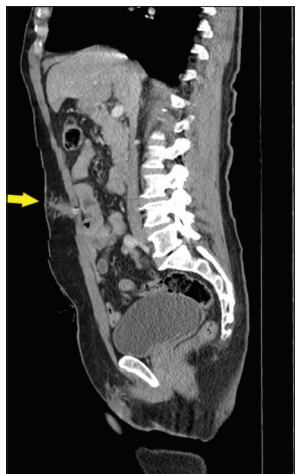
The yellow arrow indicates the peri-umbilical stab wound area on the sagittal plane of the CT scan. CT: Computed tomography
